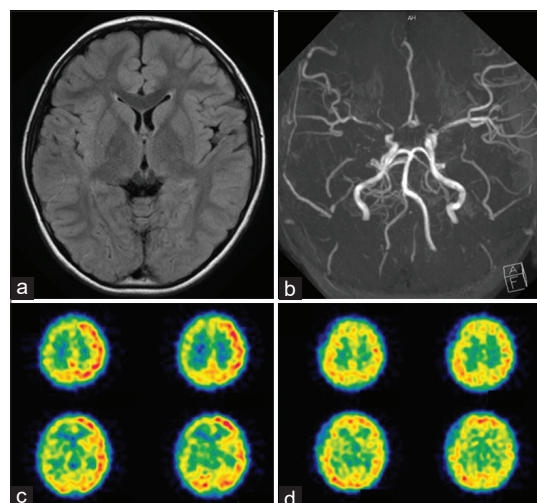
Radiological findings of a 7-year-old boy who developed oro-mandibular dystonia and transient ischemic attack (Case 1). (a) No parenchymal lesions were observed on FLAIR image (b) Magnetic resonance angiography showed the narrowing of the carotid forks and their branches on both sides. Moyamoya vessels were more apparent in the right side. (c) ¹²³I-IMP SPECT demonstrated a marked decrease in cerebral blood flow (CBF) on the right side, including the striatum and cortex. (d) On follow-up SPECT at 4 months after superficial temporal artery to middle cerebral artery anastomosis and encephalo-duro-myo-arterio-pericranial synang onto the right side, CBF markedly improved on the operated hemisphere.
